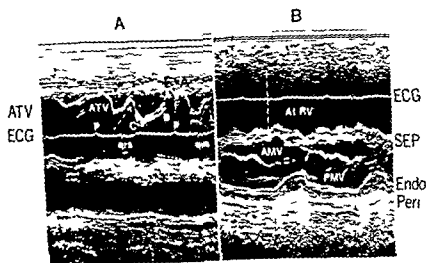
Echocardiogram from a 14 year old patient with Ebstein's anomaly of the tricuspid valve. A shows three distinct movements of the tricuspid valve. Following the P wave the valve reopens at point A and then assumes a semiclosed position. The valve reopens immediately after the QRS complex and then delayed closure occurs at point C. Abbreviations: ATV anterior tricuspid valve. B shows the large atrialized right ventricle (AtrRV) and an abnormal flat (type B) septal motion. Abbreviations: SEP septum, AMV anterior mitral valve, PMV posterior mitral valve, Endo endocardium and Peri, pericardium.
